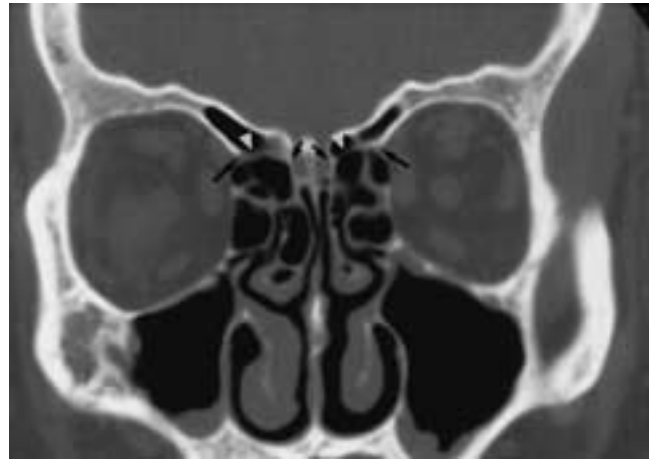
Coronal CT scan. “Dehiscent” anterior ethmoidal arteries bilaterally. When the supraorbital ethmoid cells are well pneumatized, the AEA and AEC are well seen. Note the medial (*small arrows*) and lateral (*large arrows*) portions of the canals. No bone is seen around either the right or left AEA (*white arrowheads*).
